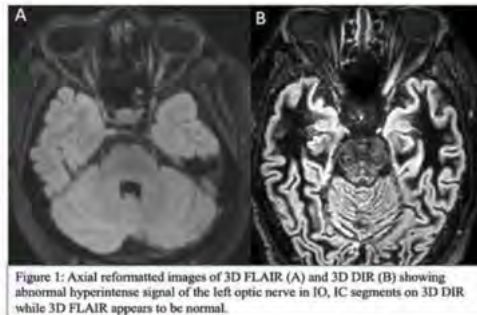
Axial reformatted images of 3D FLAIR (A) and 3D DIR (B) showing abnormal hyperintense signal of the left optic nerve in IO, IC segments on 3D DIR while 3D FLAIR appears to be normal.
